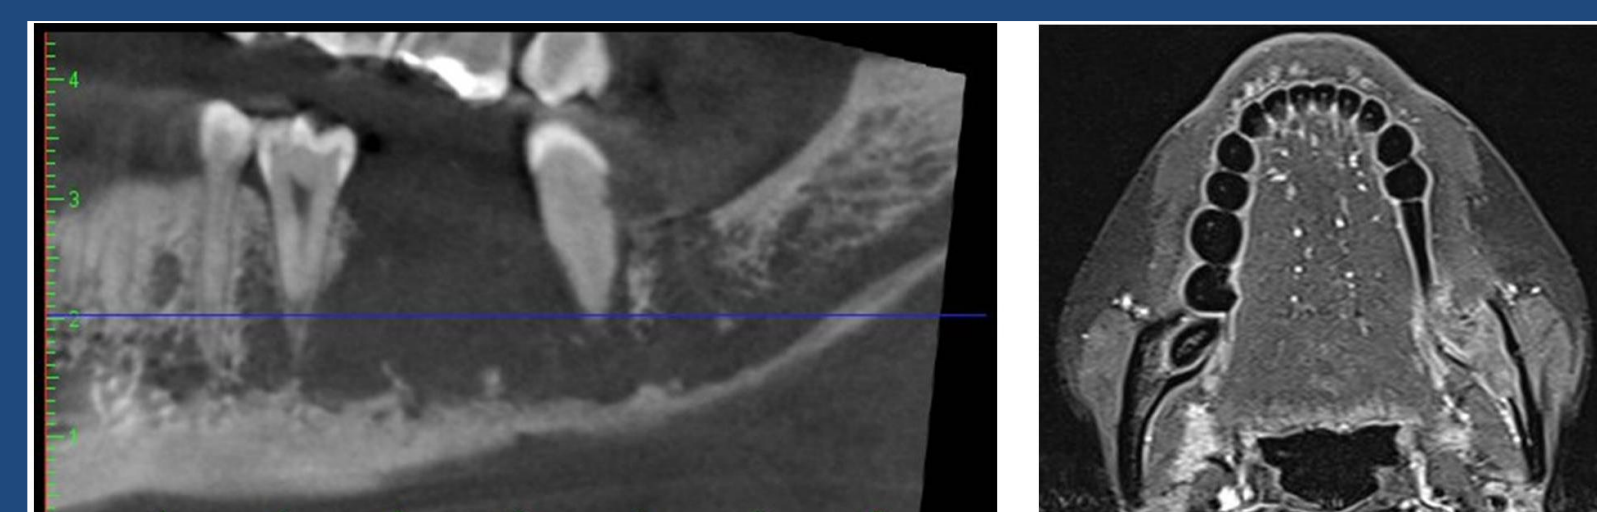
Sarcoma A) CBCT B) MRI
